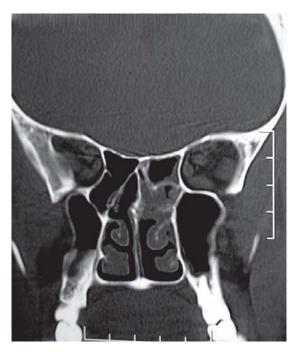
Plain CT PNS coronal cut at level of posterior ethmoids showing polyps
